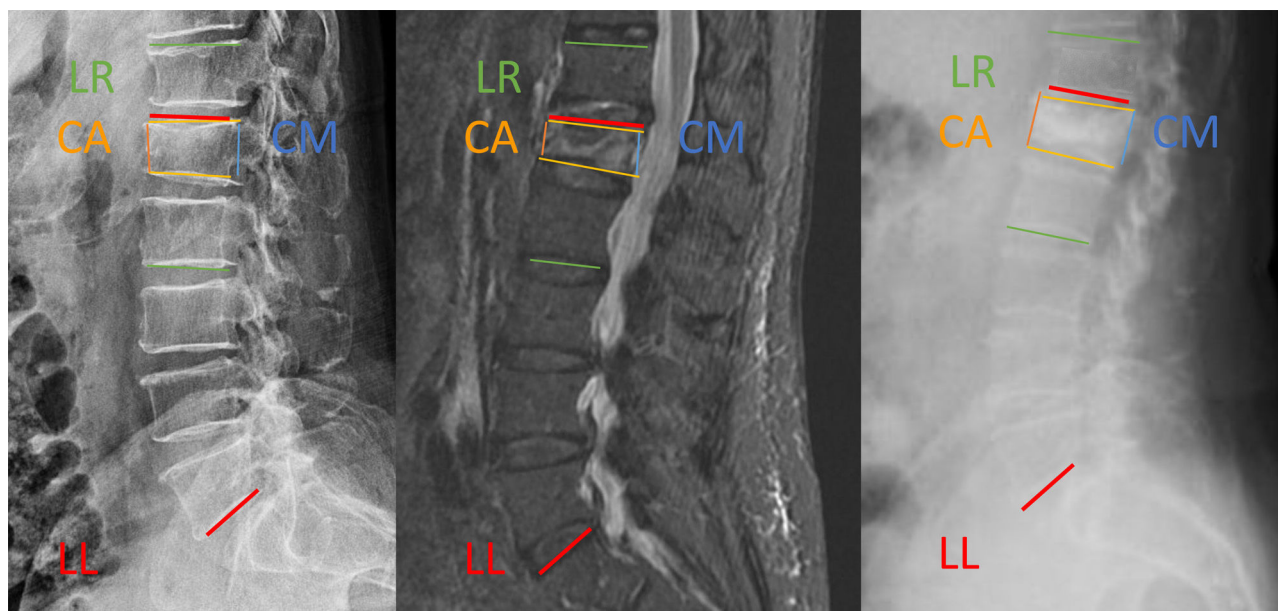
Rx PreQx; MRI PreQx; Rx PostQx: A. PreQx AC height: 7 mm; B. PreQx CM height: 13 mm; C. PreQx kyphosis: 28.8°. AA. Post-Qx AC height: 13 mm; BB. PostQx CM height: 18 mm; CC. PostQx kyphosis: 22.9.
